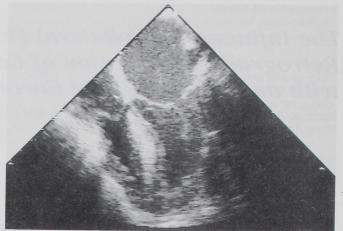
Two-dimensional transesophageal echocardiogram of the right ventricular free wall, the apex, and the interventricular septum. The transducer was positioned to provide an echocardiographic window to view the right ventricular free wall, the interventricular septum, and the apex without shadowing or dropout of these regions. Note lateral wall dropout in this image.
